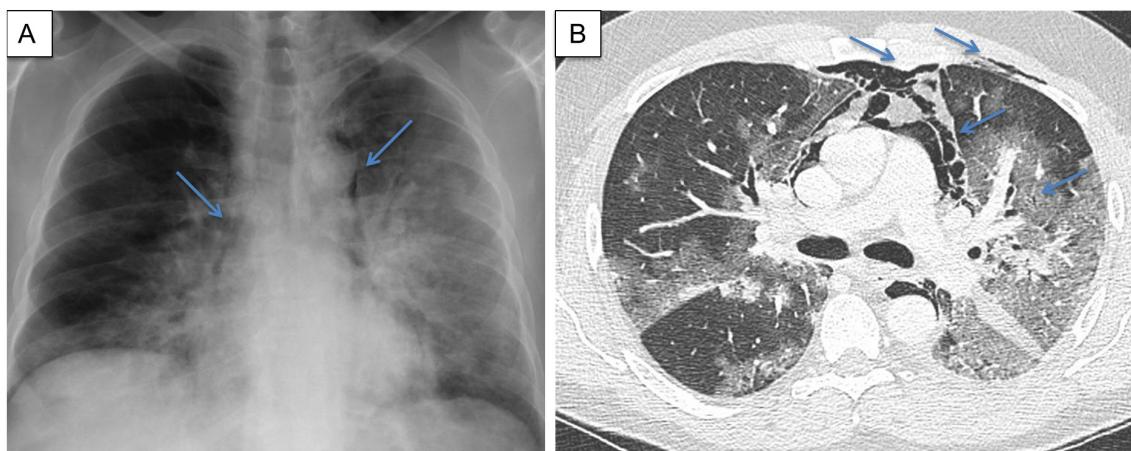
A, B. (A) Chest radiography showing bilateral opacities with left lung predominance and a paracardiac air stripe (arrows). (B) Axial computed tomography through the middle chest, viewed at lung windows, showing bilateral ground-glass opacities in both lungs, with greater severity in the left lung, subcutaneous emphysema, and pneumomediastinum involving the left pectoral area (arrows).
